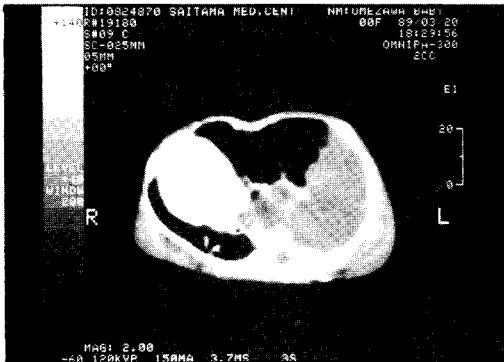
Computed tomography taken on day 2 after birth demonstrates a marginal clear-cut mass in the left posterior part of the lower lobe consistent with a CCAM.
